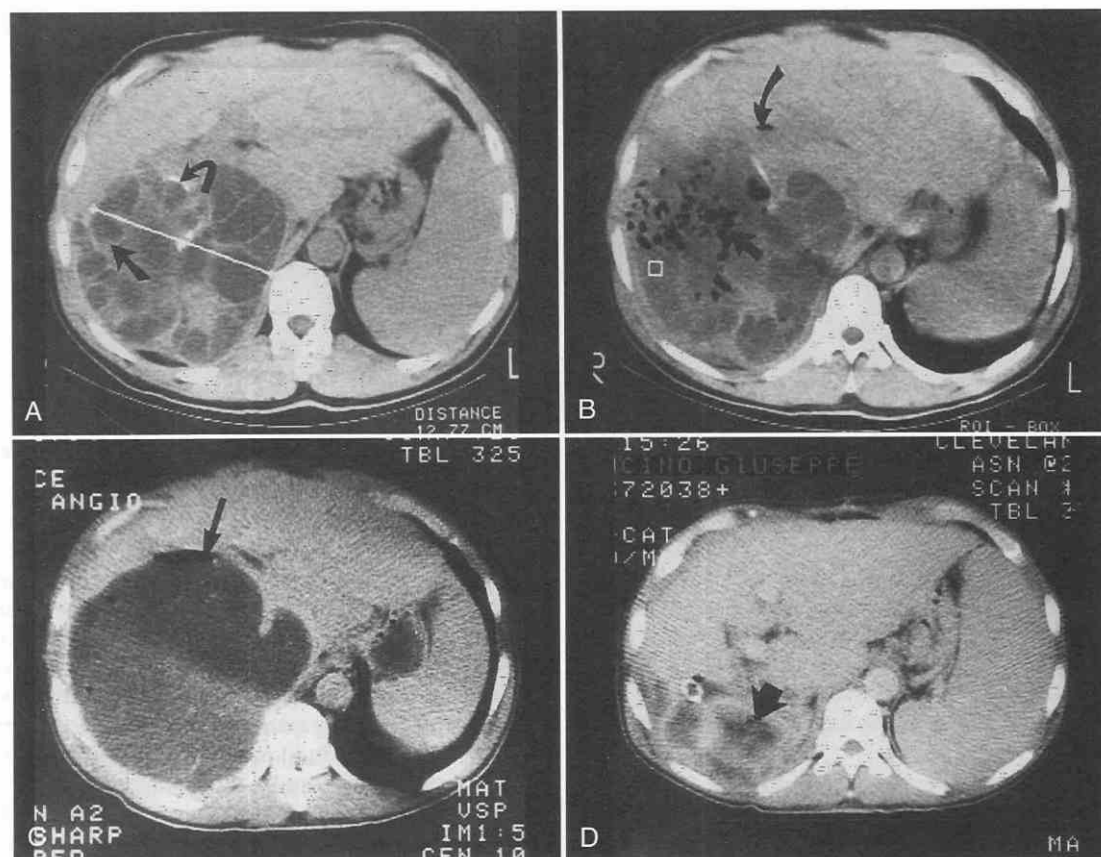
Echinococcal cyst evolution with treatment. A, CT scan of echinococcal cyst shows calcification in the wall (curved arrow) and daughter cysts (arrow) within the mother cyst. B, After secondary infection, air can be seen within a cyst. This scan shows multiple air pockets within the cyst and air within the biliary system (curved arrow). C, With persistent infection, dissolution of the daughter cysts can be seen. Note the air (arrow) in the upper portion of the cyst and the absence of daughter cysts. D, After surgery, the cavity, filled with fat-density omentum (arrow), can be seen.
